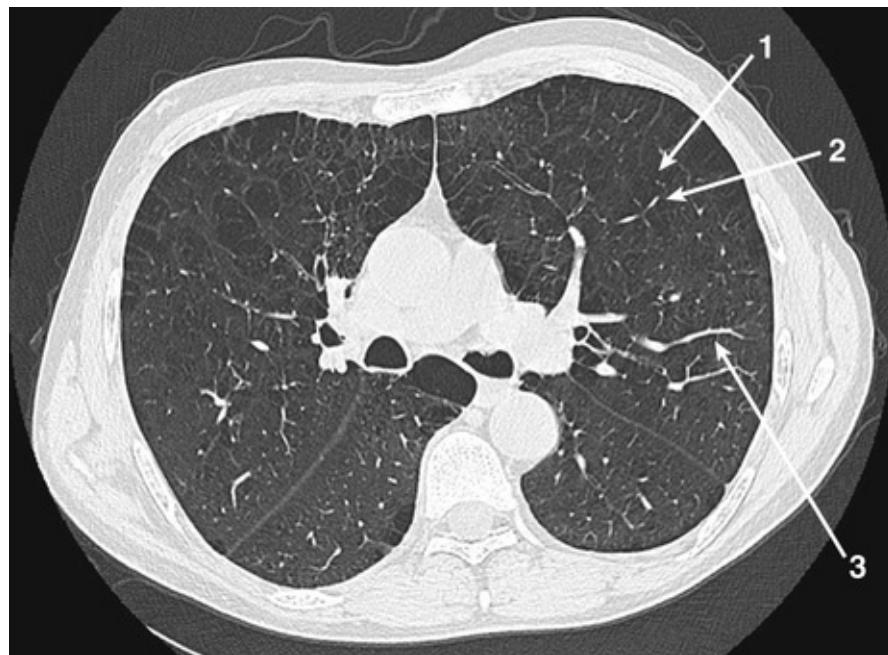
CT lung window settings. CT of a 74-year-old man with a long history of COPD. The scan shows multiple bullae surrounded by thin walls (1). Notice the blood vessels in the affected areas of the lung (2) which appear thinner than the normal blood vessels (3).
